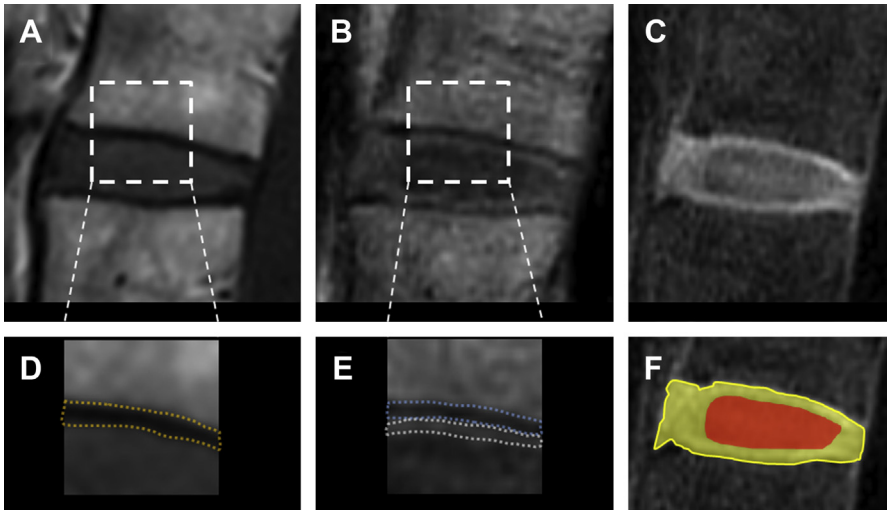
Comparison of a standard Cartesian T1-weighted scan (A) and a spiral T1-weighted research scan using Dixon technique (B, C). In (A) the endplate appears as one dark band, while on the in-phase spiral image (B) it is separated into an upper darker and lower brighter layer, which may represent the real endplate and the annulus fibrosus, respectively. These structures are blown up and highlighted in (D) and (E); blue dotted line delineates the endplate and white dotted line the annulus on (E). The water-only image of spiral scan (C) shows an outer brighter and a central darker component, likely representing the annulus fibrosus and the nucleus pulposus of the intervertebral disc. These are highlighted in yellow and red in (F). This more detailed image of the intervertebral disc and the vertebral body may provide useful diagnostic information in the early phase of the evolution of degenerative spine disease, as it may visualize annular tear, endplate changes, and early formation of disc herniation.
